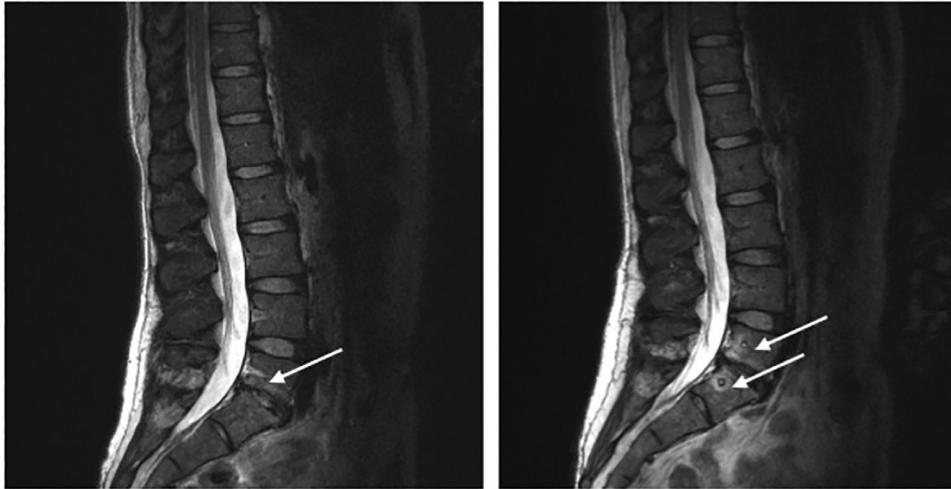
Example of pre and post treatment T2-weighted MRI. (Left) Baseline MRI showing Modic changes at L5–S1 vertebral endplates. Arrow points to terminus of BVN at L5. (Right) Six-week post-treatment MRI arrows showing RF ablation lesion.
